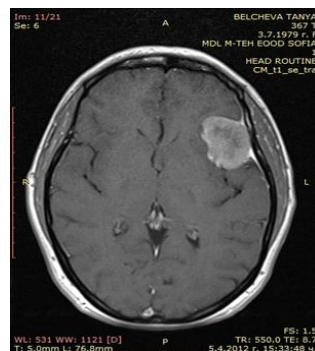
MRI of meningioma of the greater wing of the sphenoid bone
